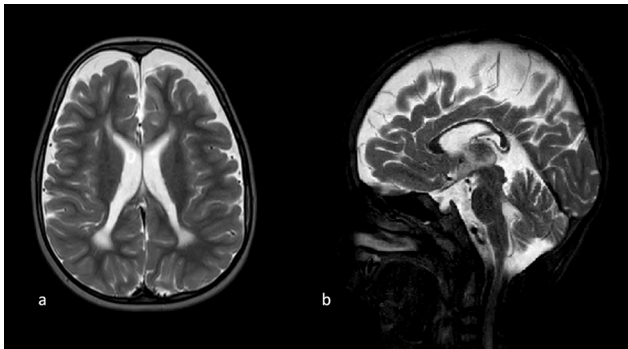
T2W MRI images in the axial and sagittal planes in a PVL case show periventricular abnormal high signal areas, increased peripheral CSF distance anteriorly, ventricular wall irregularities, mild ventriculomegaly, white matter volume loss, and corpus callosum thinning
